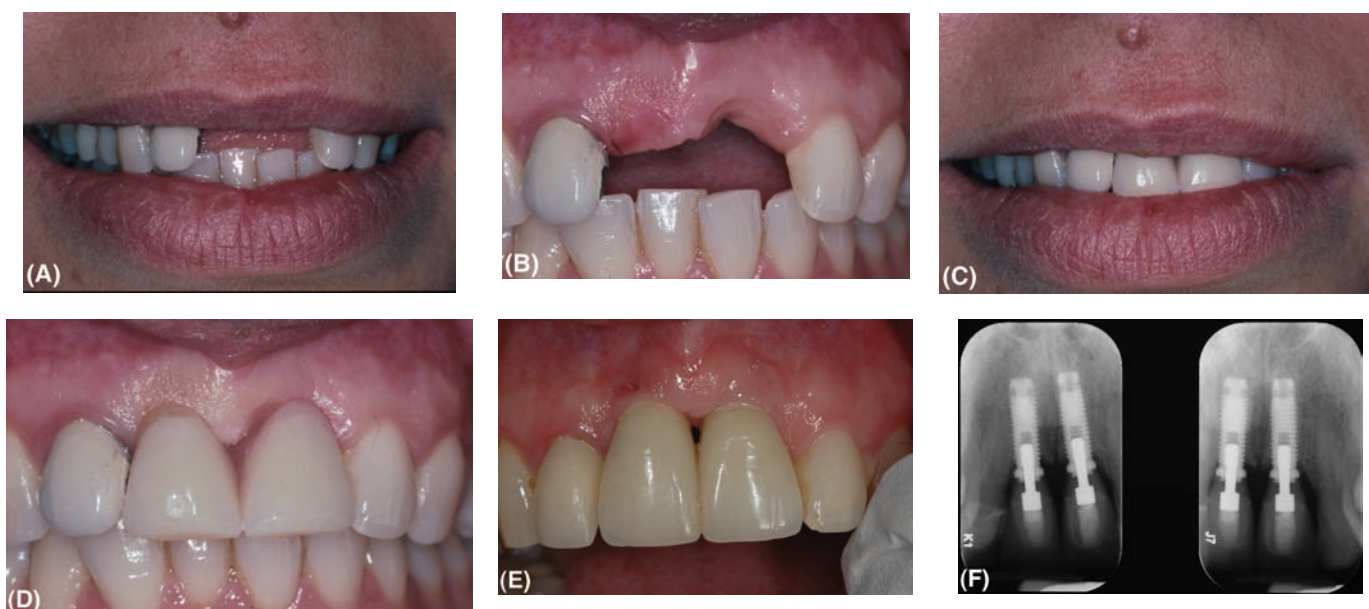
(A) A patient with missing maxillary central incisors following loss of a fixed prosthesis. (B) The intraoral view showing good ridge height at tooth 11 but loss of vertical height at tooth 21. (C) The patient with a diagnostic denture in place with lips at rest. (D) The intraoral appearance of the diagnostic denture. There is no labial flange and the discrepancy in ridge height between teeth 11 and 21 is less obvious. This patient was treated without the ridge augmentation. (E) The same patient treated with single tooth implants after a period of eight years. The clinical crown heights of the central incisors are symmetrical but longer than the adjacent natural teeth. (F) The radiographs eight years following treatment showing ideal bone levels at the first thread of the Branemark implants. The abutments and crowns are ceramic.
